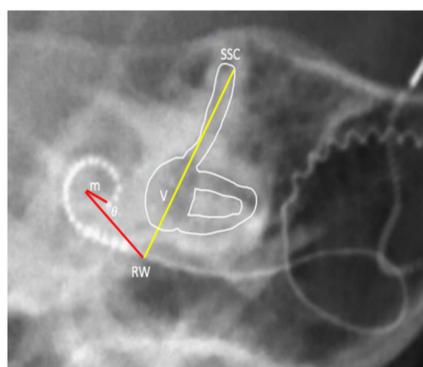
Measure of DOI on cochlear view x-ray.
